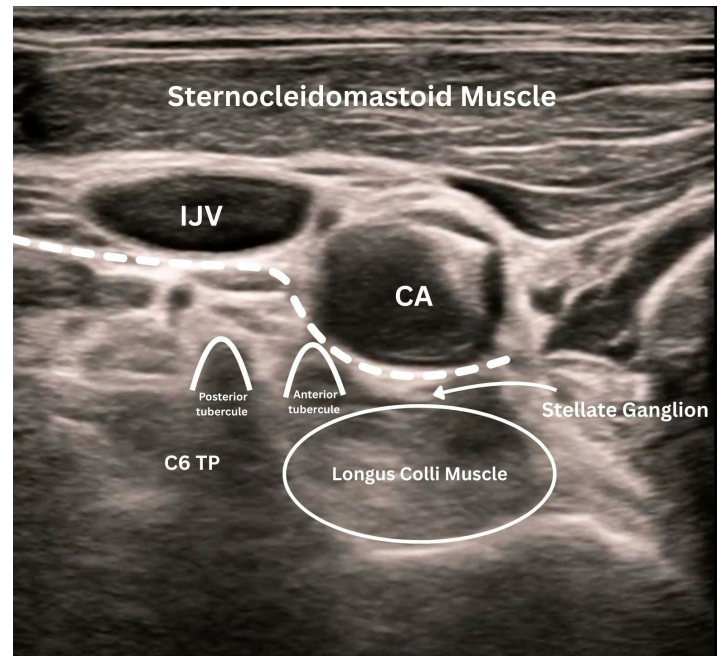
Ultrasound image of neck anatomy, with the dotted white line indicating prevertebral fascia.
